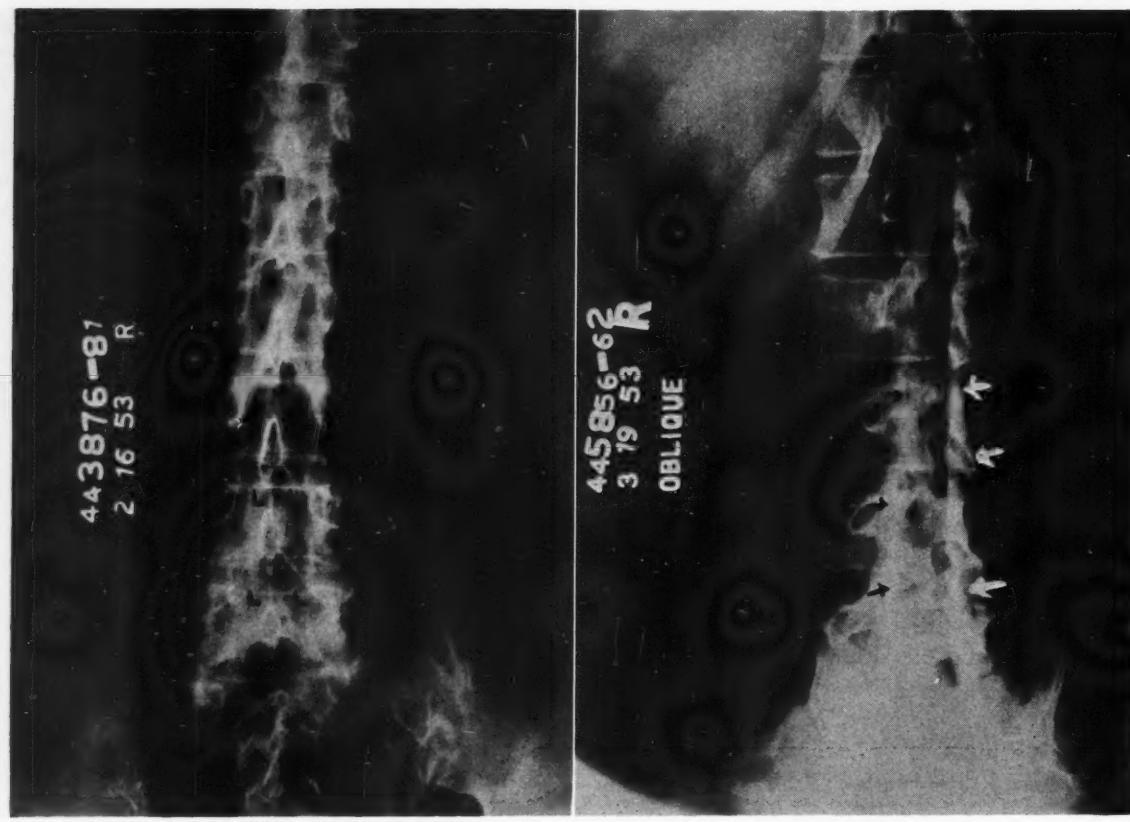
A, anteroposterior roentgenogram of lumbar spine. Note the calcification in the ligamenta flava (letters L overlying these structures between the third and fourth and fourth and fifth lumbar vertebrae). Similar changes exist in the ligamenta flava between the neural arches of the upper lumbar vertebrae. B, right posterior oblique roentgenogram of lumbar spine. The white arrows point to the calcified ligamenta flava. The black arrows indicate the loss of definition of the apophyseal joints, with narrowing of the joint spaces.
